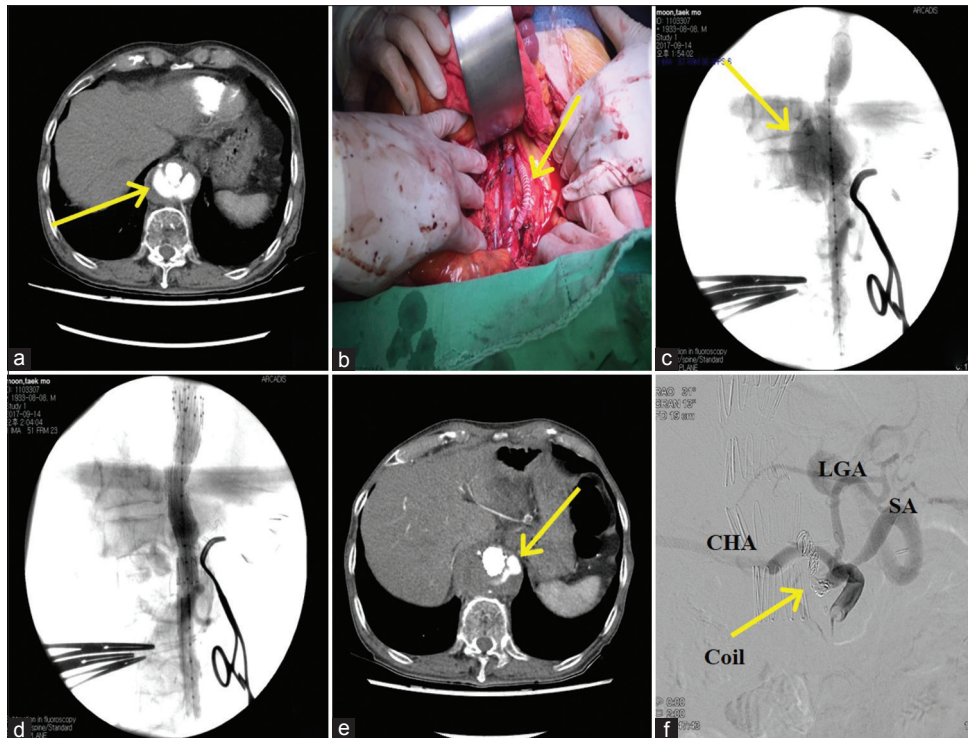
Hybrid management for SCAA was successfully performed in an 84-year-old high-risk male. (a) Cross-sectional view of preoperative CTA showing SCAA. Arrow indicates SCAA. (b-d) Intraoperative findings showing the hybrid procedure including aorto-celiac axis bypass with PTFE and TEVAR; arrows indicate patent PTFE (b) and aneurysm (c). (e) Postoperative CTA showed persistent endoleak at 6 weeks postoperatively. Arrow indicates endoleak. (f) Coil embolization for persistent endoleak was performed. Arrow indicates coil. SCAA: Supraceliac aortic aneurysm; CTA: Computed tomography angiography; PTFE: Ring-reinforced polytetrafluoroethylene; TEVAR: Thoracic endovascular aortic repair.
